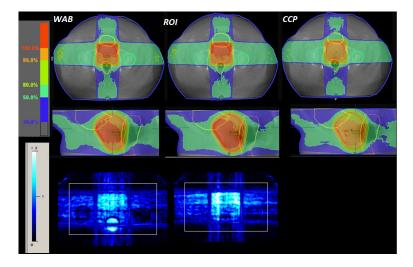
Comparison of dose distribution for transversal and sagittal planes for a bad case prostate case (7). Due to high BMI of patient and limited size of FOV, CBCT images are cropped compared to planning CT images. In the third row  $\gamma$ -values are shown, were ROI is marked yellow.
